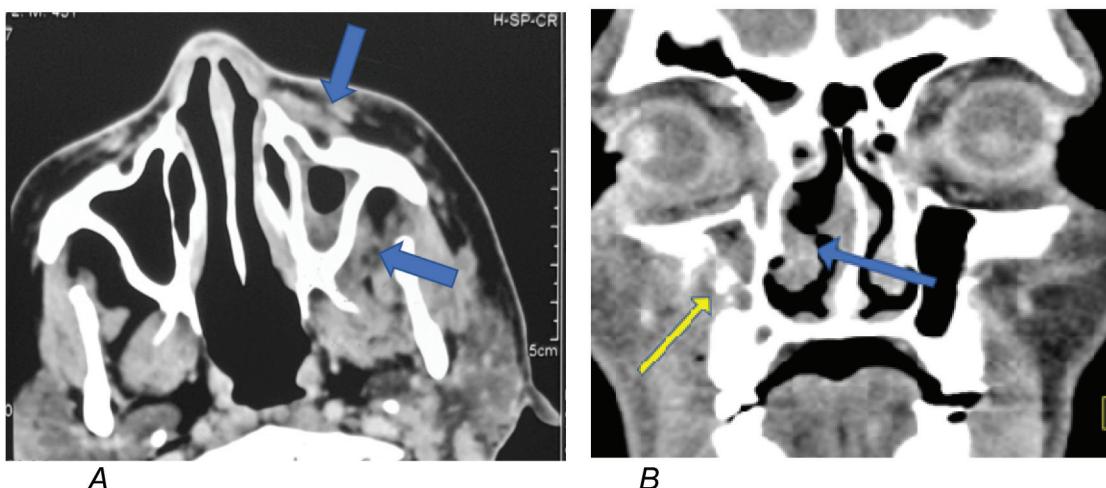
Imaging finding in acute invasive fungal rhinosinusitis: A: Axial CT shows left maxillary sinus mucosal thickening with peri-antral fat stranding without intervening bone destruction in a case of AIFRS. Note the retroantral fat plane infiltration is also in proximity to pterygomaxillary fissure and pterygopalatine fossa. B: Coronal CT shows ulcerated mucosal thickening in right nasal cavity (blue arrow) and maxillary sinus mucosal thickening with bone destruction (yellow arrow) in a case of AIFRS
